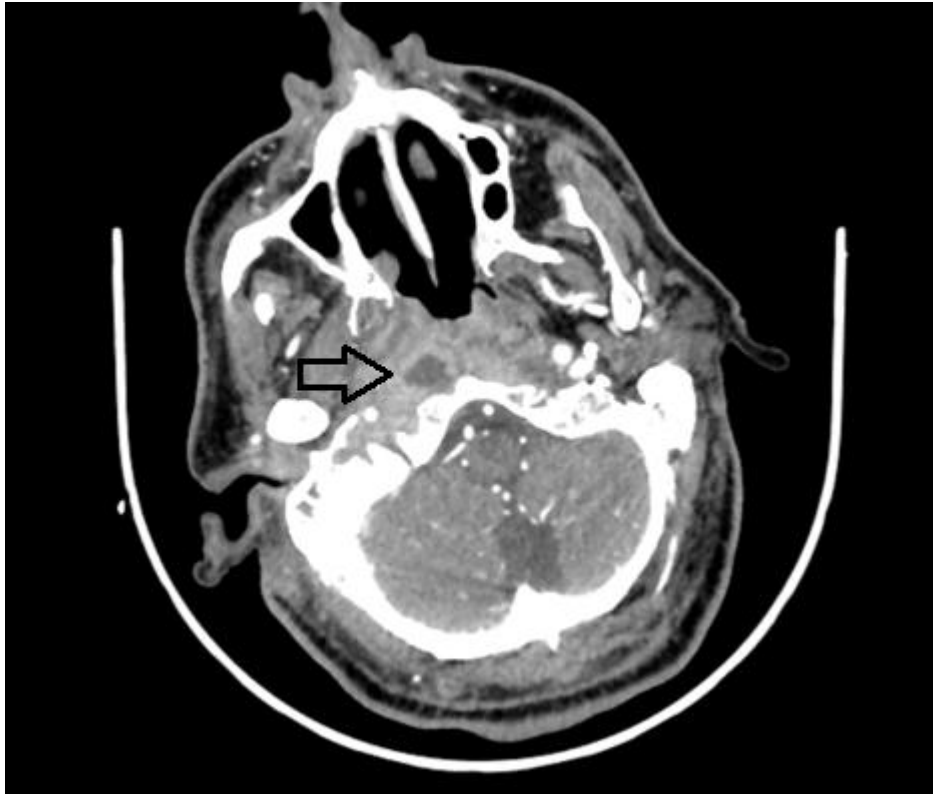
Carotid CT Angiography showing a 10×15×16 mm lobulated contoured hypodense lesion with dense peripheral contrast enhancement in the right retropharyngeal area extending into the right prevertebral area.
